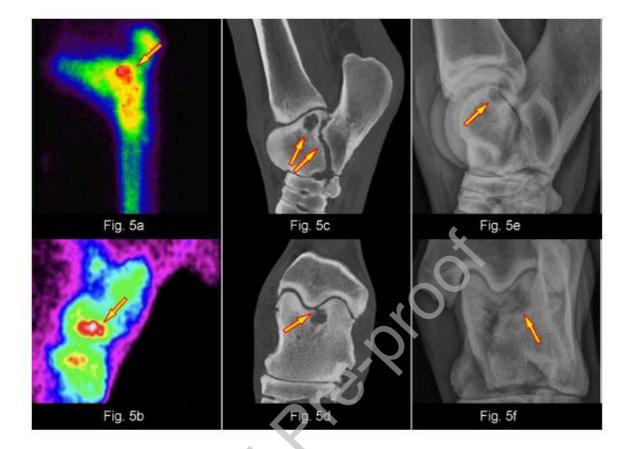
Lateral (a) and dorsal (b) scintigram of the left hock show localized increased uptake of radionuclide (yellow arrow). Computed tomography exam, frontal plane (c) of the talocrural joint shows a subchondral cystic lesion (yellow arrow). Sagittal plane (d) shows a cystic lesion communicating with joint surface and talocalcaneal osteoarthrosis (yellow arrows).
